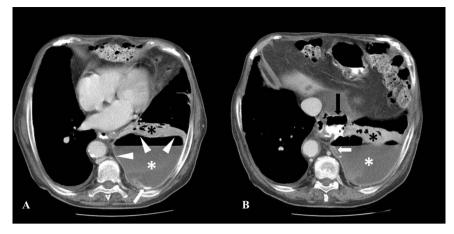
CT scan performed on admission. Water soluble contrast has been administered by mouth. (a) A left large loculated pleural effusion filled with purulent fluid and air is evident (white asterisk). The wall of such collection in thickened and hyperaemic (arrowheads). The black asterisk shows the atelectatic lower lobe of the lung. (a), (b) A small amount of contrast leaks from the mediastinum into the pleural collection (white arrows). (b) A large amount of contrast mixed with air is filling a para- oesophageal mediastinal collection (black arrow).
